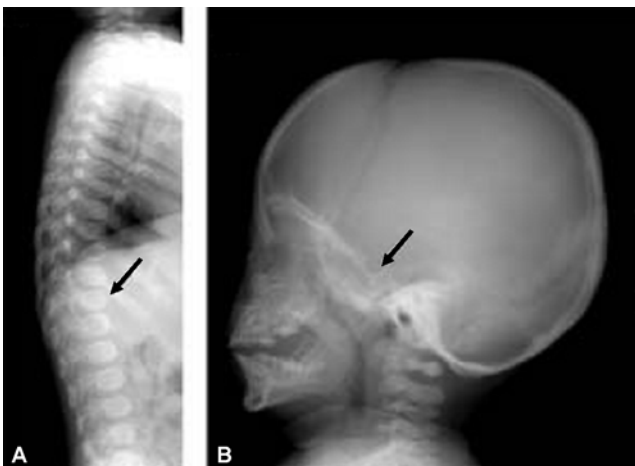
The X-rays show an anterior beak (arrow) hook-shaped vertebrae (A), J-shaped sella turcica (arrow), odontoid hypoplasia and suspicious narrowing of the spinal canal in the C-spine (B).
